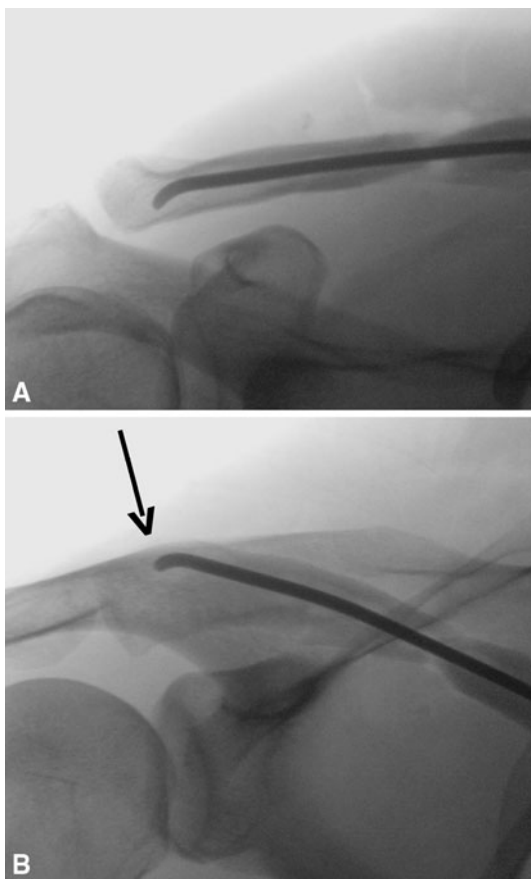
Intraoperative radiographs show (A) a correct lateral advancement of the TEN in the AP view and (B) a possible lateral perforation in the oblique view (*arrow*). TEN = titanium elastic nail.
